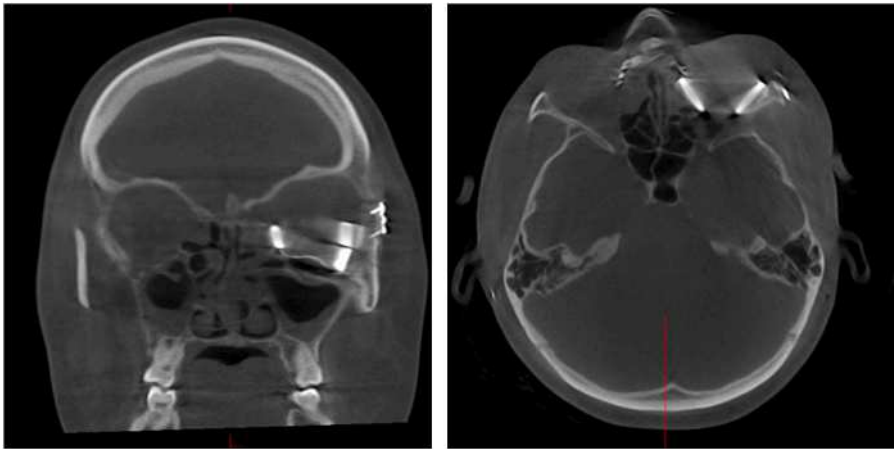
The CT image (coronal view) reveals the PSI and 3 spacers in the left orbit. The CT image (axial view) shows the exact position of the spacers on the medial and lateral orbital walls. (Source Figure 3C&D - Spalthoff S, Dittmann J, Zimmerer R, et al. Intraorbital volume augmentation with patient-specific titanium spacers. J Stomatol Oral Maxillofac Surg 2020;121(2):133–9.)
